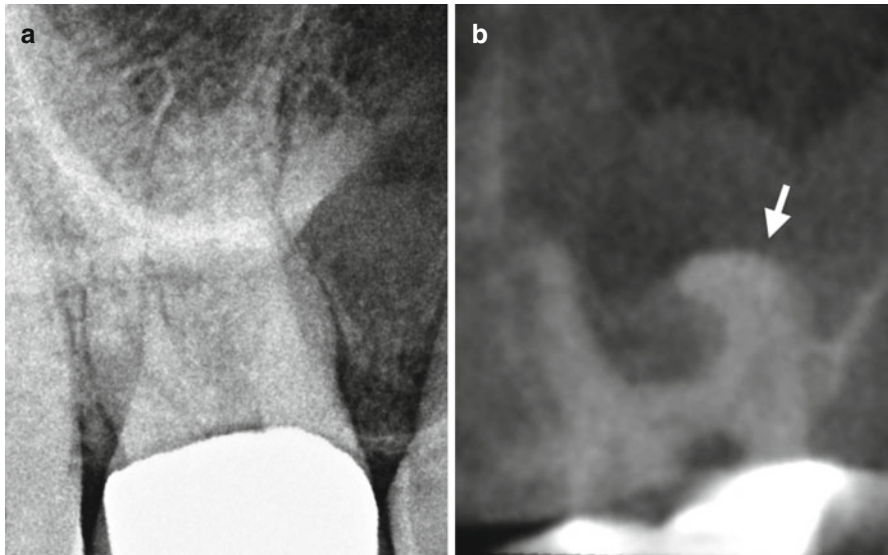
Periapical radiograph of a maxillary right first molar (a) with a corresponding coronal CBCT slice demonstrating a significant curvature of the mesiobuccal root in the buccopalatal plane (white arrow) (b)
